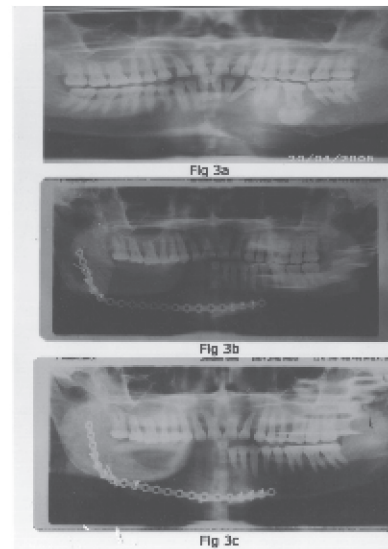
a=preoperative OPT showing multilocular radiolucency with periapical radio-opacity around the first molar roots with destruction and expansion of the mandibular inferior border. b=OPT after resection and immediate fixation of 2.4 locking titanium reconstruction plate c= OPT after delayed (3 months postoperative) cortico-cancellous iliac crest bone graft.
